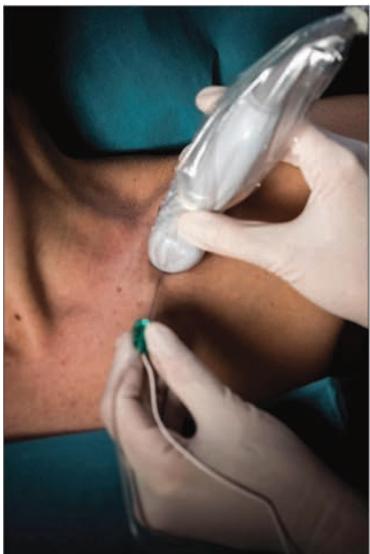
Reverse ultrasound anatomy with an alternative needle insertion (in-plane), from medial to lateral. AA, axillary artery; AV, axillary vein; MC, medial cord; LC, lateral cord; PC, posterior cord; R2, second rib.
